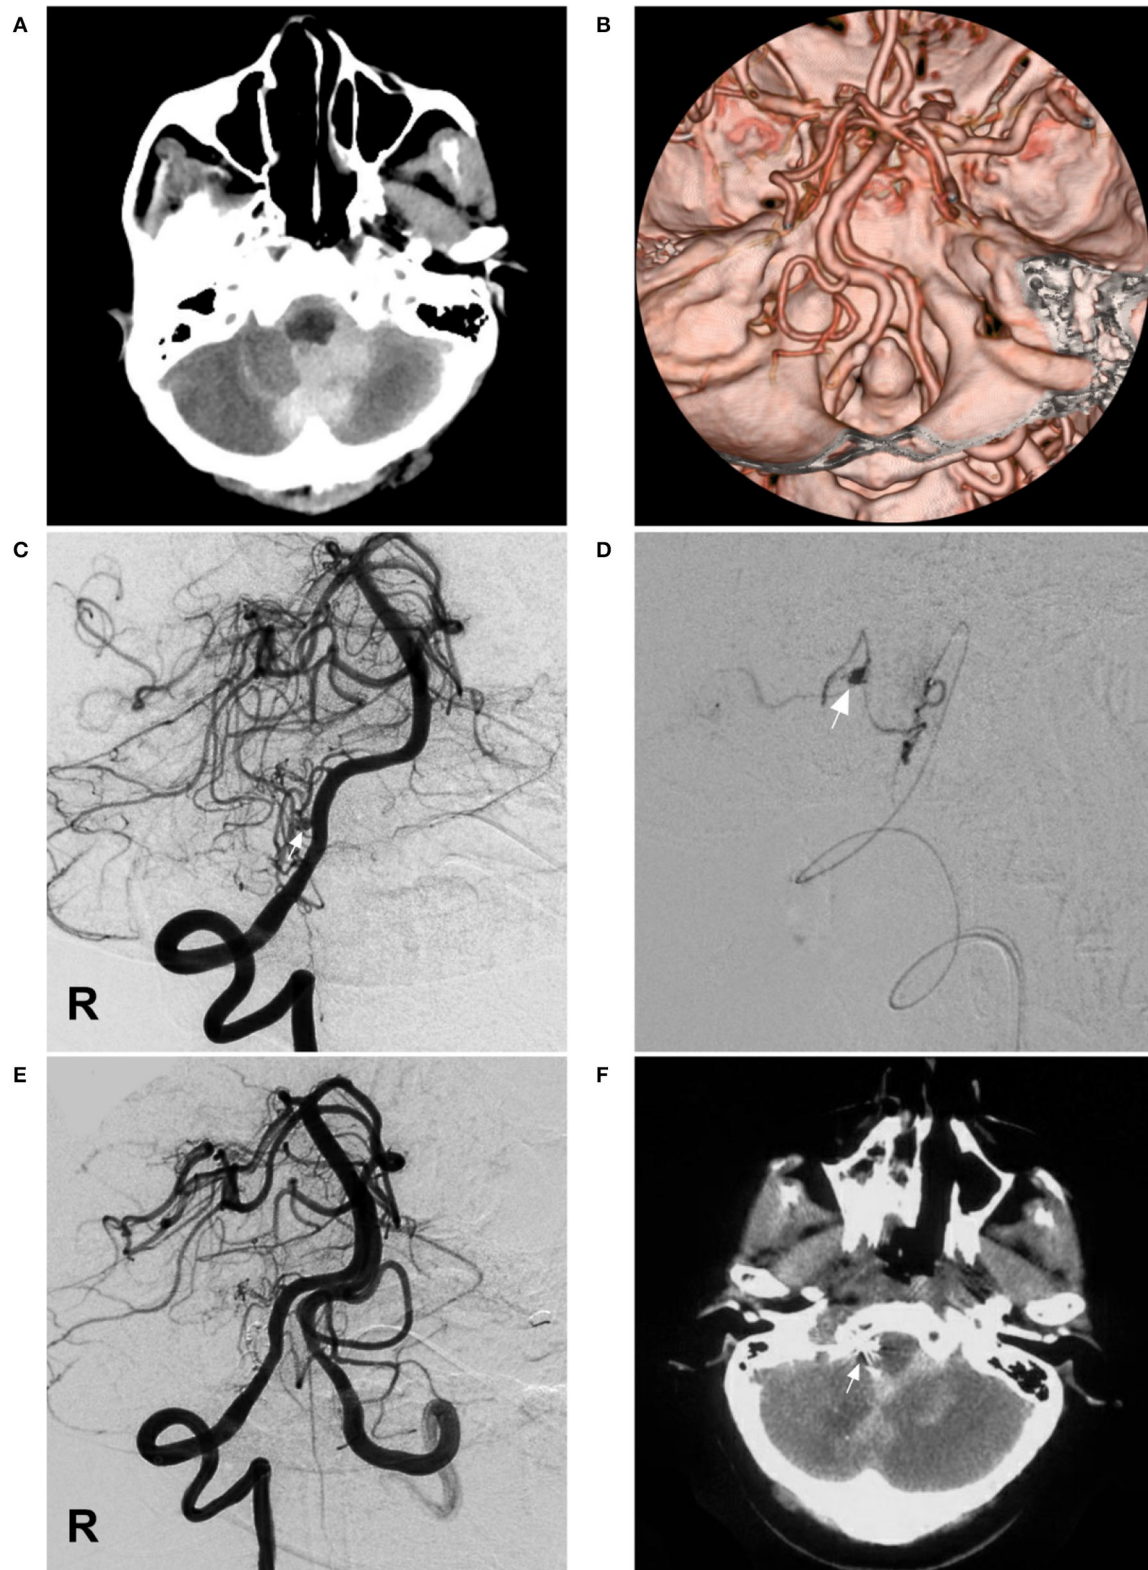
Imaging of case 2. (A) CT shows SAH concentrated at the cisterns around the brainstem and cerebellomedullary cistern. (B) CTA reveals no vascular abnormalities. (C) Angiogram of the right VA shows a pseudoaneurysm (arrow) located in the hypoplastic and plexiform PICA. (D) Superselective angiogram of the right PICA showing the pseudoaneurysm (arrow). (E) Angiogram of the VA shows that the aneurysm and parent PICA were cast with Onyx, and other branches are visualized. (F) Postoperative CT scan shows the location of casting Onyx (arrow) and partial resolution of the SAH. CT, computed tomography; CTA, CT angiography; PICA, posterior inferior cerebellar artery; R, right; SAH, subarachnoid hemorrhage; VA, vertebral artery.
